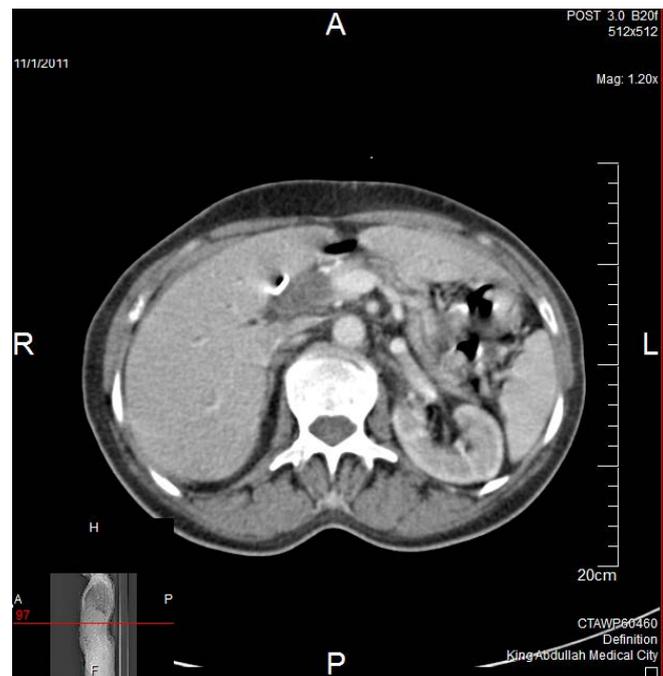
CT abdomen showing no hepatic focal lesions with reduction in the soft tissue mass at the surgical bed
